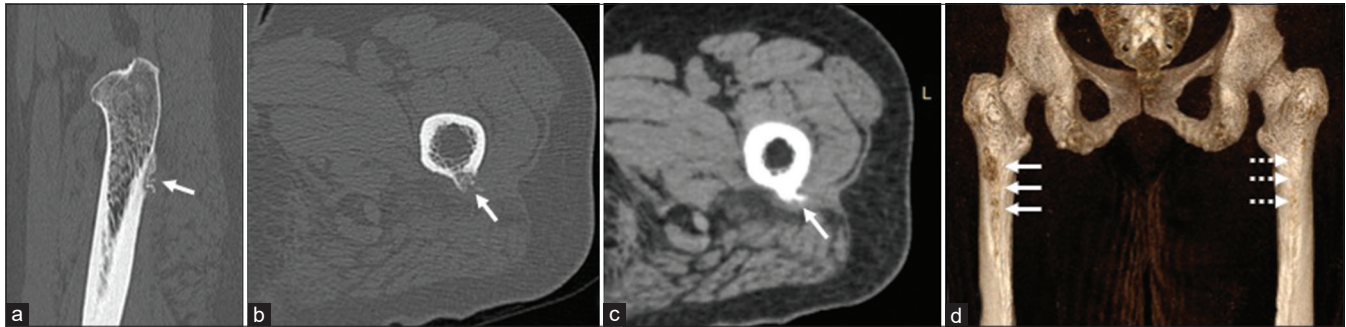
A 55-year-old female with upper thigh pain. (a-c) Coronal oblique and axial CT in bone window and soft-tissue windows show focal cortical irregularity, bone proliferation along the gluteal tuberosity and linea aspera, soft-tissue thickening. (d) Volume rendering of bilateral femurs posterior aspect shows thickening and irregularity along the linea aspera (solid white arrows). Dotted white arrows represent normal linea aspera for comparison.
